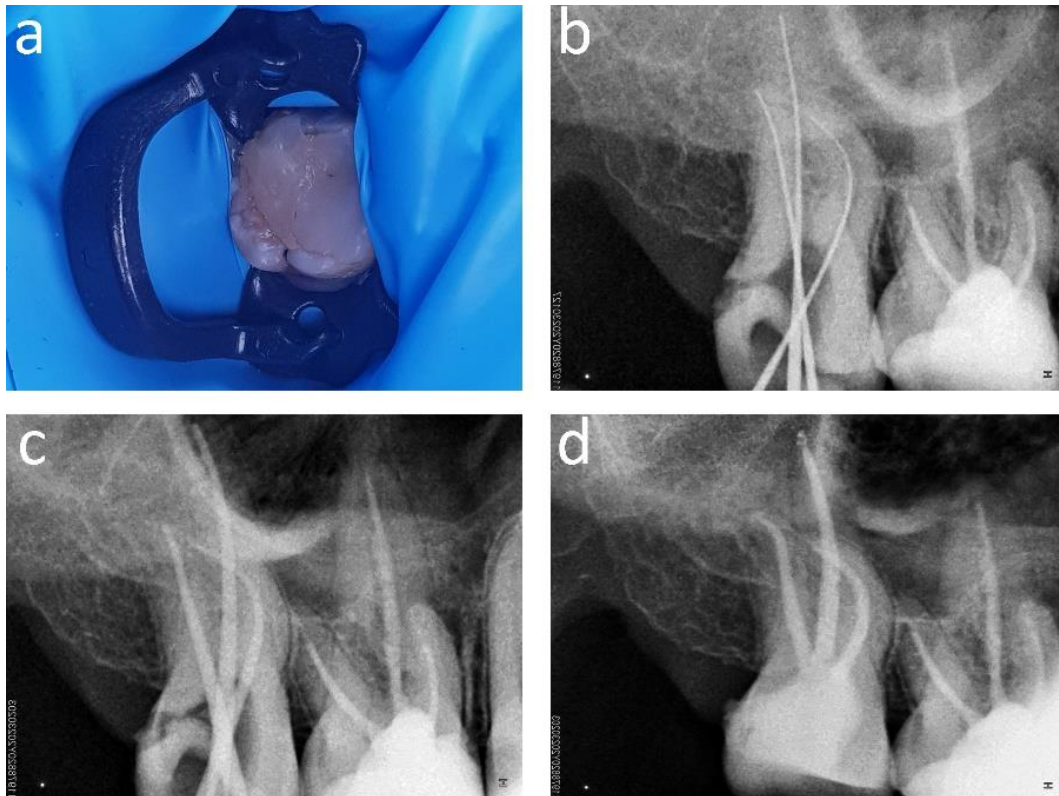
(A) Isolation; (B) working length x-ray; (C) gutta-percha trial; (D) obturation.
